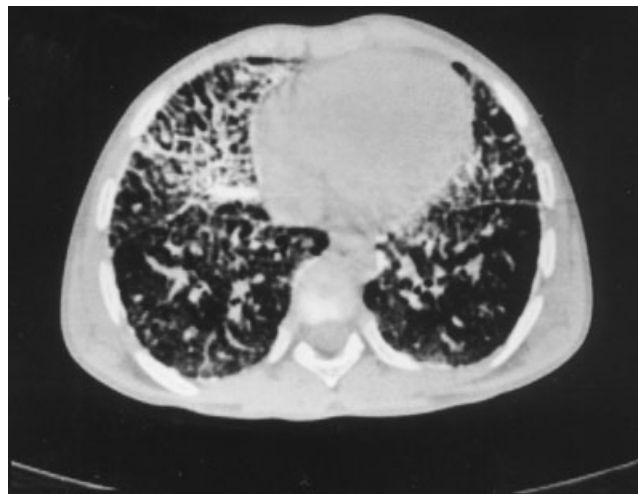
High-resolution CT of the thorax (4- and 2-mm scans). Tiny, firm miliary consolidations, primarily in an alveolar setting, can be seen symmetrically, mainly hilopetally in both lobes of the lungs. Interstitial fibrous changes in the form of netlike and stripped interstitial beams are also present, predominantly in anterior segments of lung lobes. Elements of retractive pulmonary changes with compensatory local hyperinsufflations can also be seen.
